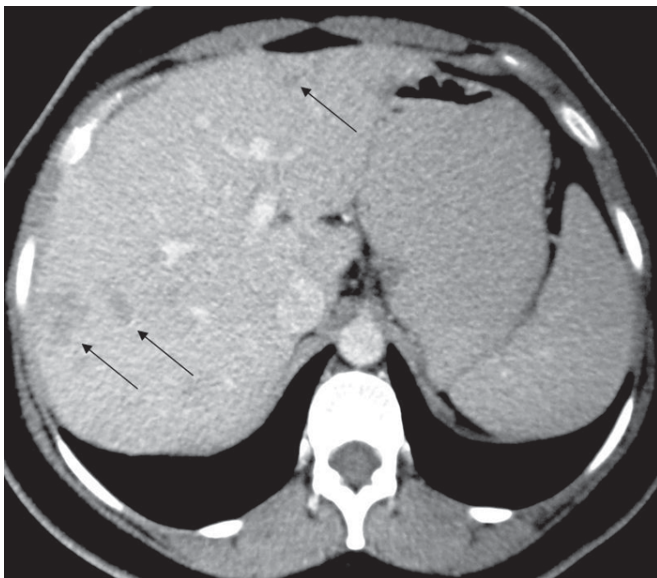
Axial contrast-enhanced CT reveals multiple ill-defined hypodense areas in both lobes of the liver (arrows). Needle biopsy of these lesions revealed the presence of caseating epithelioid granulomas suggestive of tuberculosis.
